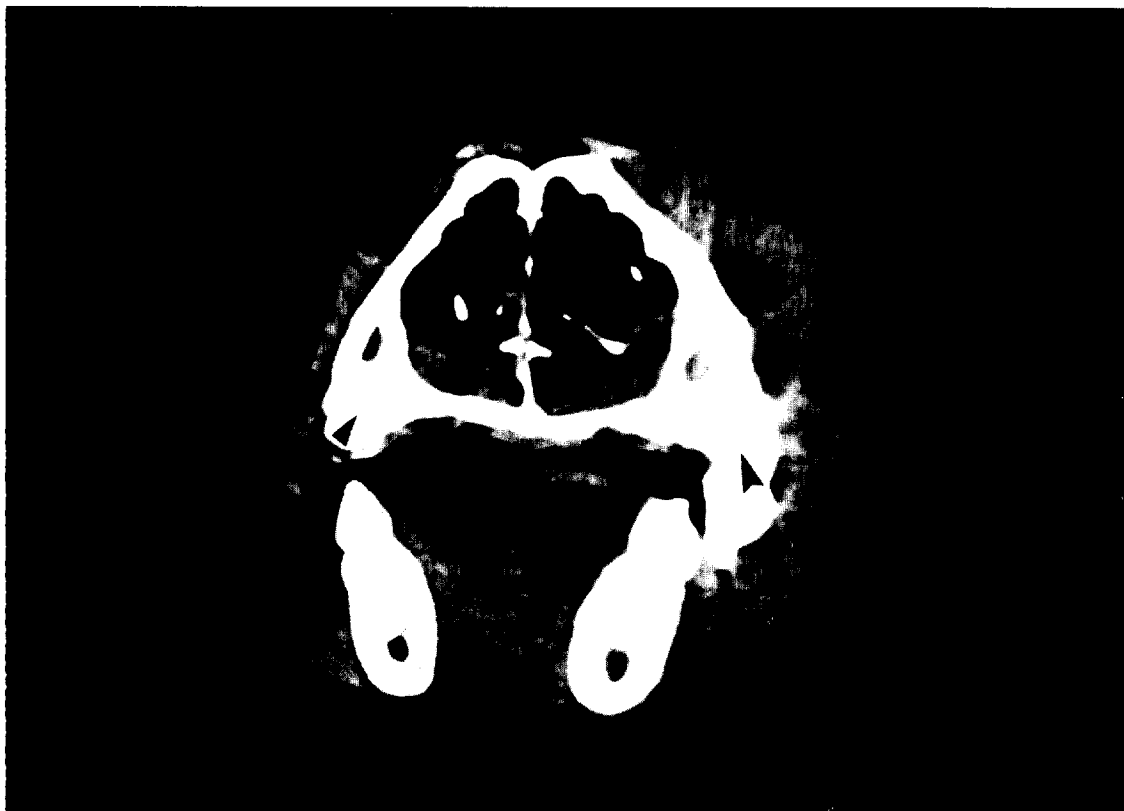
CT scan taken 6 months following bilateral sinuses grafted with TGF- β / OsteoGen, showing increase in mineralization as graft time increase (arrow).
